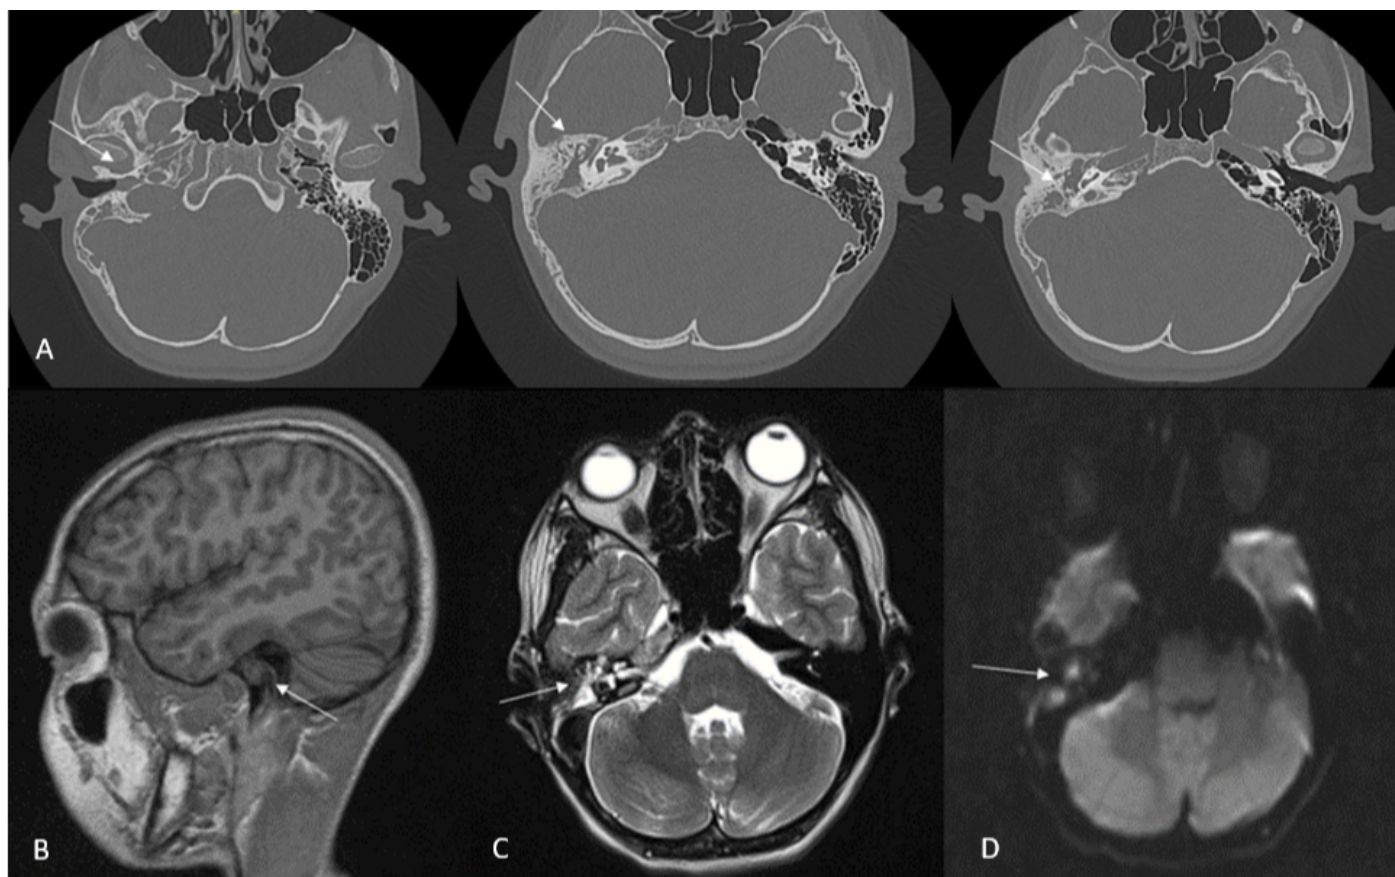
Computer and magnetic resonance tomograms of the temporal bones of a 15-year-old patient with complaints of unilateral hearing loss on the right, frequent episodes of otitis media. A – Computer tomograms of the temporal bones in the axial projection. In the external auditory canal, parietal contents are determined. The mastoid process, antrum and attic are filled with pathological contents, the contours of the mastoid cells have marginal erosions. The density of the auditory bones is reduced, the incus has uneven contours. CT signs of external and otitis media on the right with signs of osteolysis of the auditory ossicles. To exclude the presence of cholesteatoma masses, MRI in DWI mode is recommended. The same patient, B – magnetic resonance imaging in T1-VI mode, sagittal projection, C – T2-VI mode, axial projection, D – DWI mode (b=1000), axial projection. In the area of the antrum and attic, against the background of increasing signal intensity on T2-VI, focal formations are determined, moderately hyperintense in the T2-VI mode (B), isointense in the T1 mode (A), irregular in shape with unclear uneven contours, moderately heterogeneous structure, these formations limit diffusion on DWI (b=1000) (C), confirming the presence of cholesteatoma masses in the middle ear cavity
